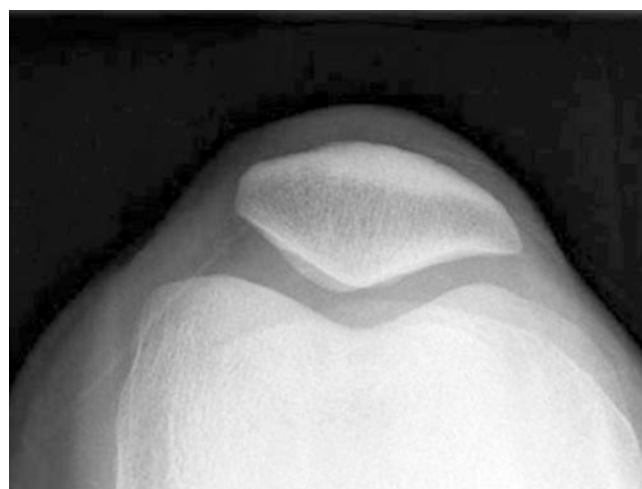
Sunrise view can show the position of the patella in the trochlear groove. Computed tomography (CT) and magnetic resonance imaging (MRI) can better delineate the tilt of the patella and trochlear hypoplasia
